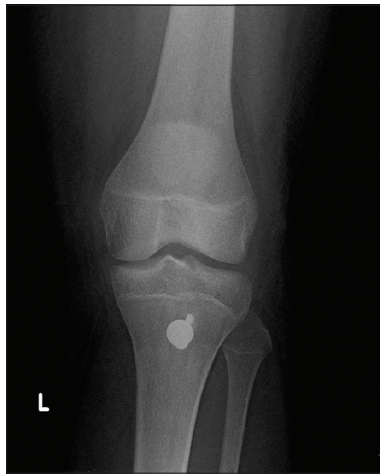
Six-month postoperative radiograph anteroposterior view
